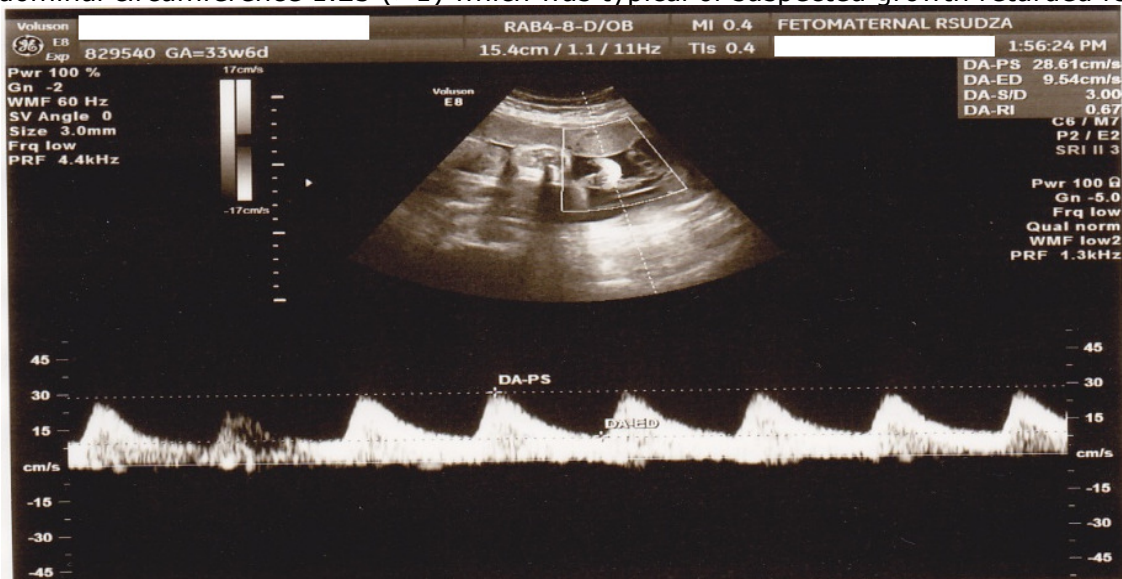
The umbilical artery Doppler showed a slight increase in ratio of systolic to diastolic of 3.00 ( $\geq 3.00$ ) indicating slight elevated resistance in umbilical artery
